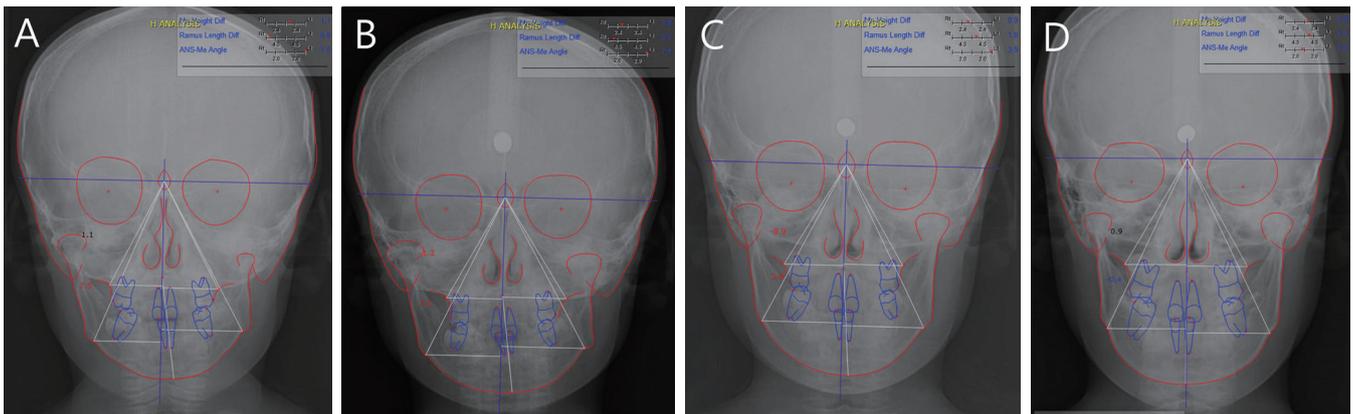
A series of Anteroposterior cephalometric radiographs. (A) Initial radiograph, (B) 1 year later radiograph, (C) 3 year later radiograph, (D) 4 year later radiograph. The growth of left mandibular condyle is seen and asymmetry is almost resolved.
